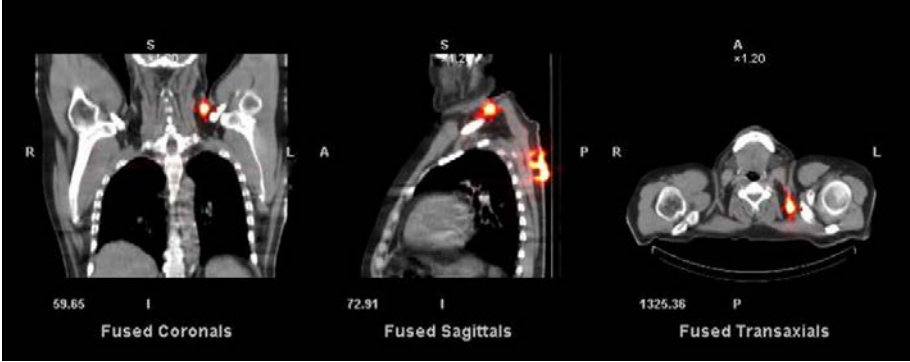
Fused SPECT/CT images obtained 2 h after injecting 111 MBq of  $^{99m}\text{Tc}$  nanocolloid in a patient with melanoma of the upper back. Lymphatic drainage to the pretrapezoidal muscle ipsilaterally is clearly identified. Stand alone scintigraphic images of the head and neck area are not informative, unless combined with anatomical data. This example shows the necessity to fuse both modalities to clearly identify unexpected anatomical locations of SLNs.
